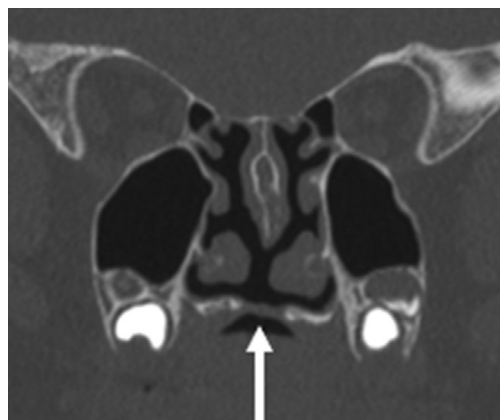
Defect of the hard palate (arrow) and short vomer in the coronal view in an X-ray computed tomography image.
